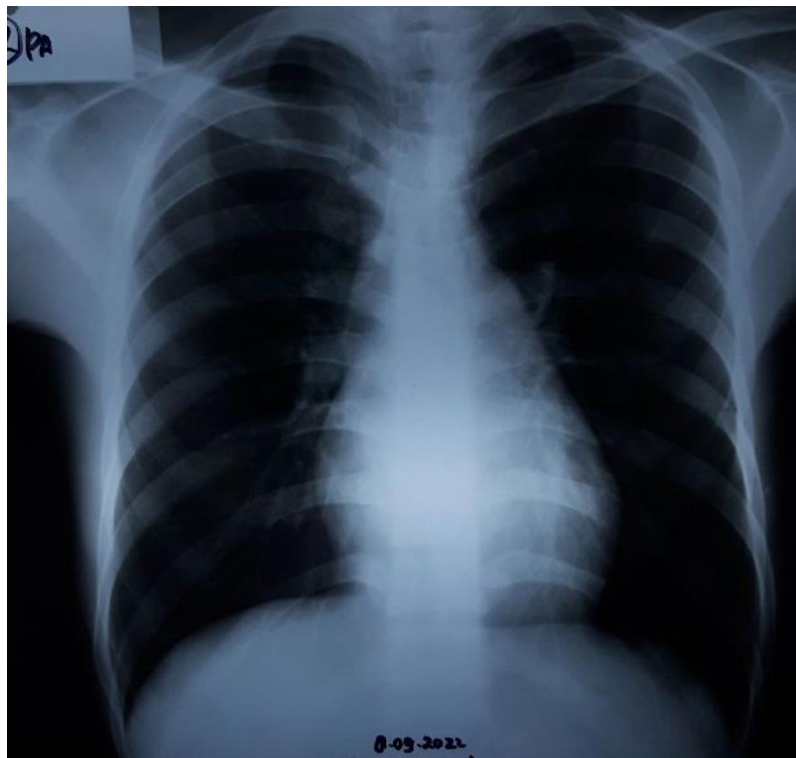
The patient's chest X-ray demonstrates unremarkable findings.
